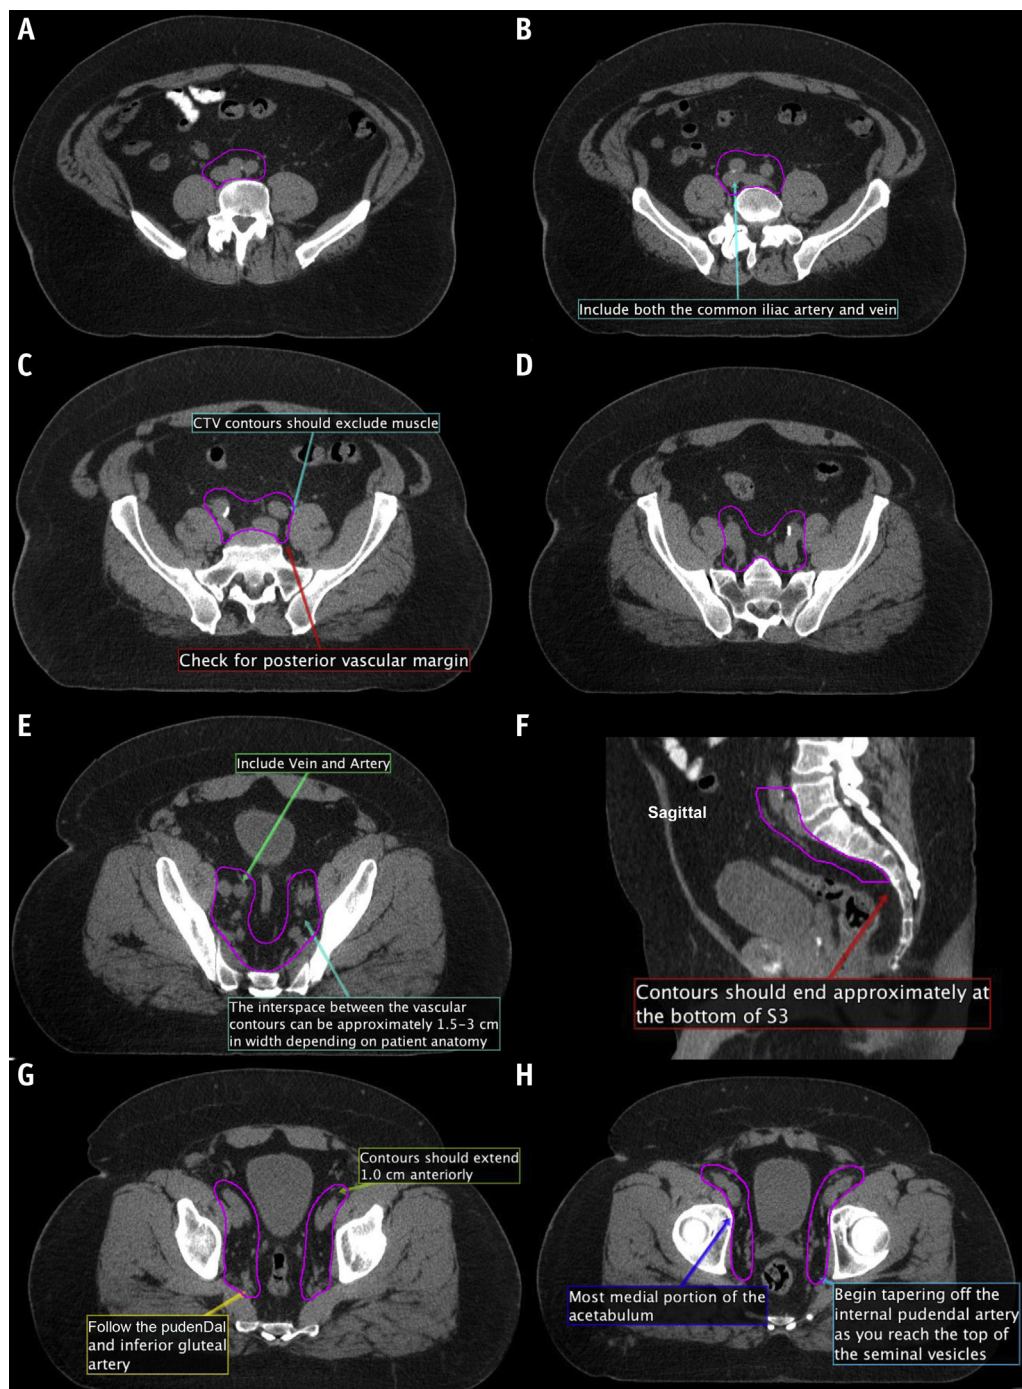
(A-M) New consensus contours on computed tomography. *Abbreviation:* CTV = clinical target volumes.
